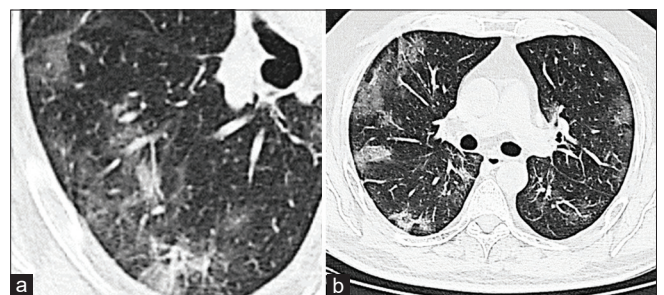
(a and b) Computed tomography scan of a coronavirus from a patient in SG Moscati showing ground-glass lesions in the lungs bilaterally soon before his situation worsened
